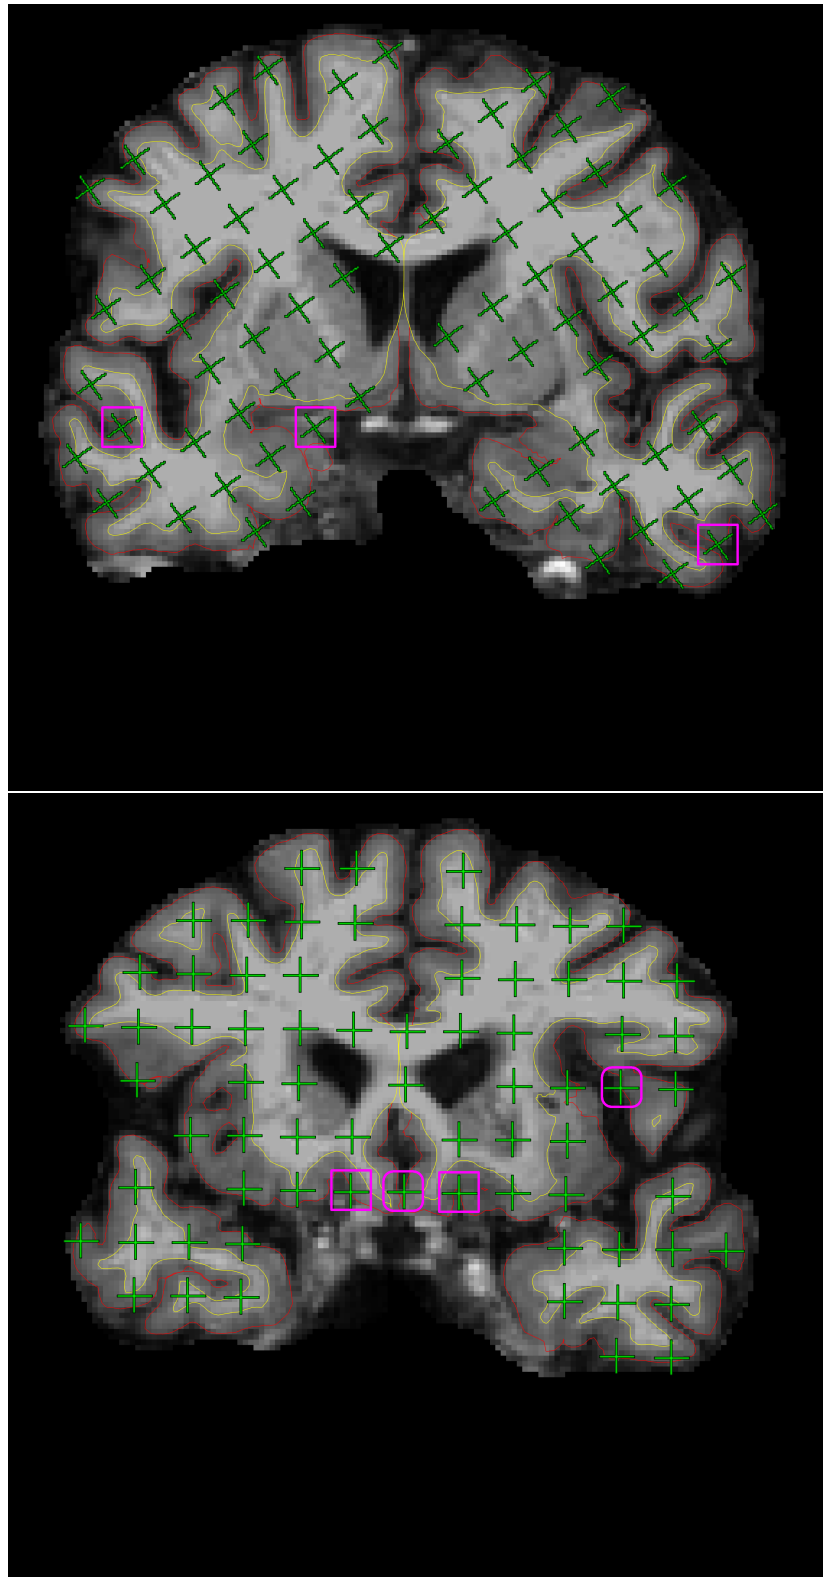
On the 11th and 12th slices of one brain MR image in the coronal view, counted test points (green) hitting the cerebrum (excluding ventricles) are overlaid onto pial profiles (red lines) segmented by FREESURFER. Rectangles (pink) mark the counted test points which fall outside the grey matter boundaries (red lines) and rounded rectangles (pink, racetrack-like) mark the test points hitting exactly on the grey matter boundaries.
